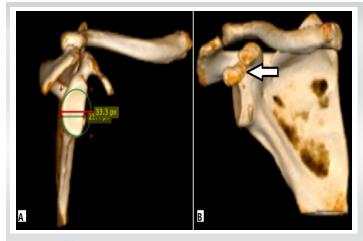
(a) computed tomography image showing glenoid bone loss of 25% and (b) coracoid avulsion fracture (arrow).
